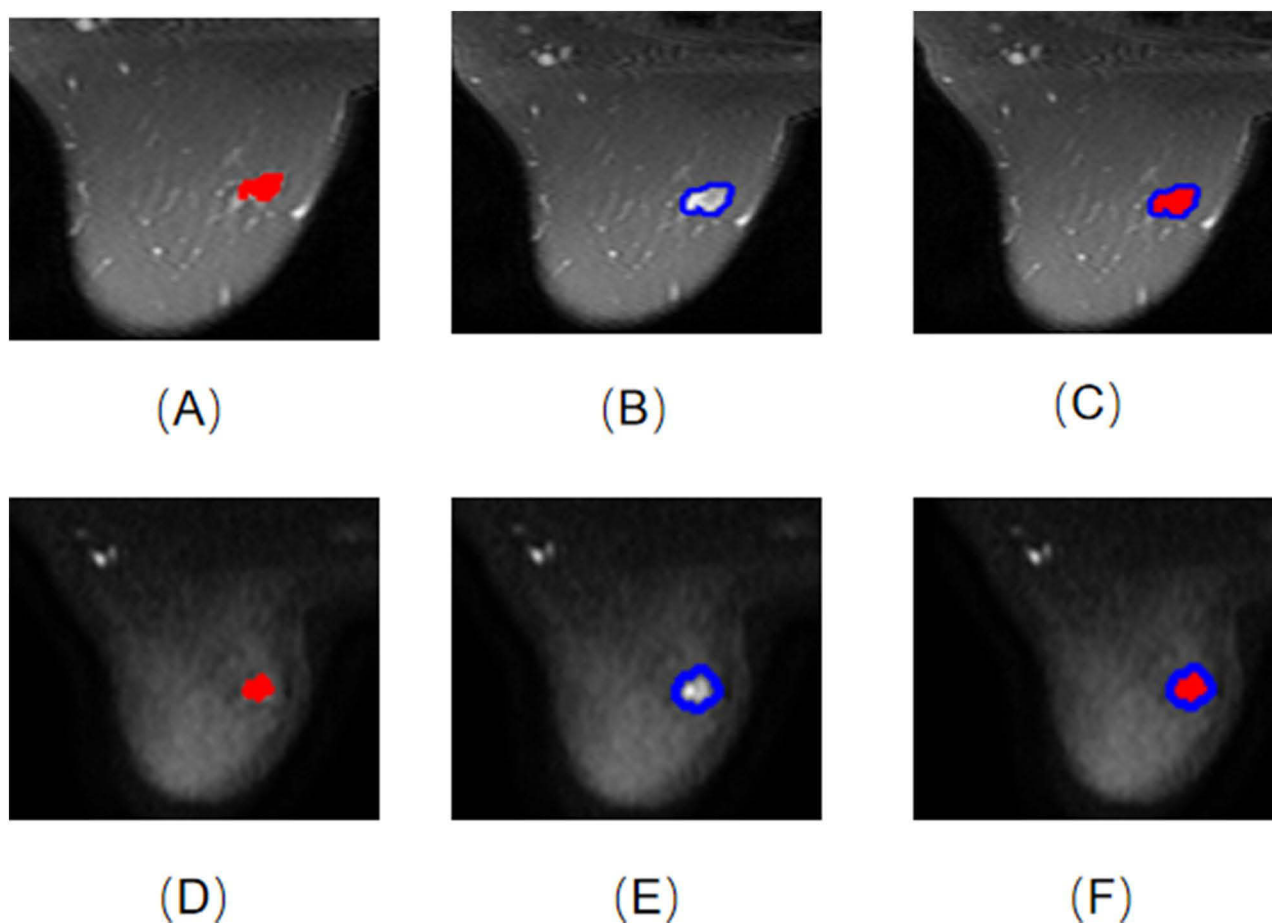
ROIs of 9 models. (A) T2WI-ITR; (B) T2WI-3mmPTR; (C) T2WI-ITR + 3mmPTR; (D) DWI-ITR; (E) DWI-3mmPTR; (F) DWI-ITR + 3mmPTR. Abbreviation: ROI, region of interest.
